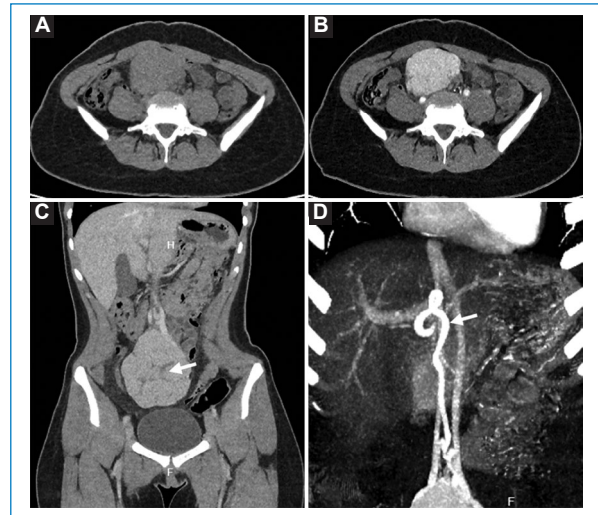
Abdominal computed tomography images with intravenous iodinated contrast showing a lobulated mass with a peduncle originating from hepatic segment III, extending into the pelvis, which is isodense to the liver in the simple (non-contrast) phase (A), with homogeneous avid enhancement in the arterial phase (B) and isodense in the portal phase (C), with a hypodense center of radial configuration that corresponds to a central scar (arrow in C). In the arterial phase with maximum intensity projection and coronal reconstruction (D), an ectatic and tortuous artery is observed (arrow) originating from the left hepatic artery, which is hypertrophic and supplies blood to the mass.
